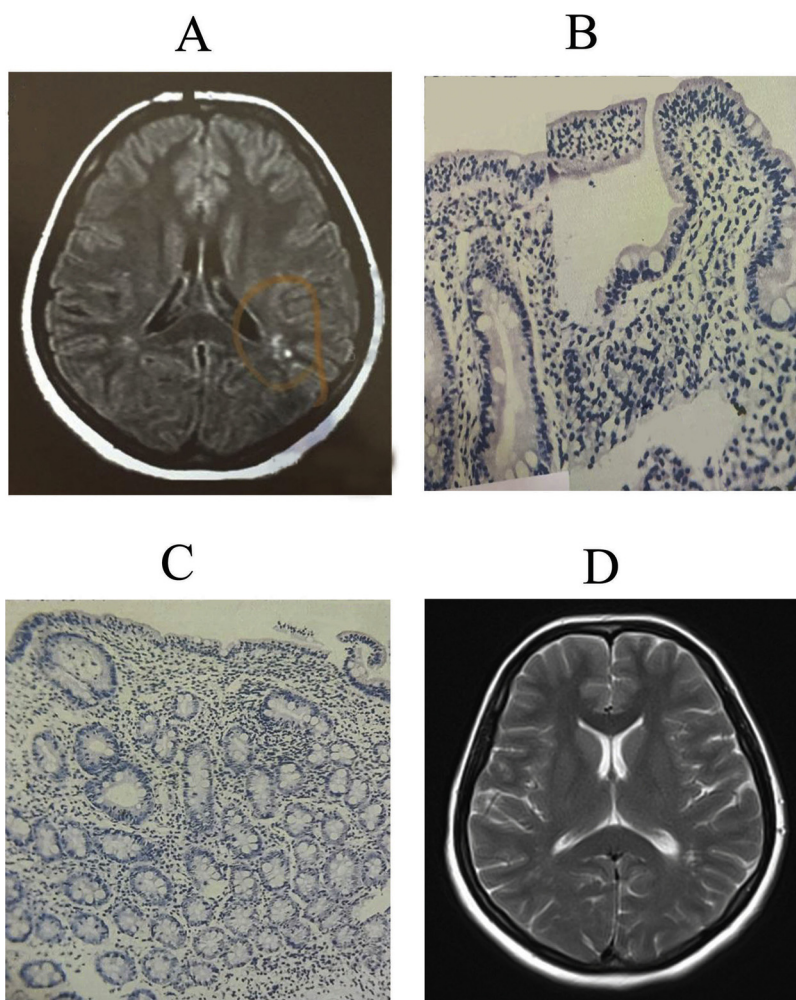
(A) Brain MRI showed nonspecific white matter lesions. (B and C) Duodenal mucosal biopsy demonstrated significant lymphocytic proliferation, crypt hyperplasia, and villi atroph. (D) The brain MRI which had been done 11 years ago had revealed some non specific bright white matter lesions.
